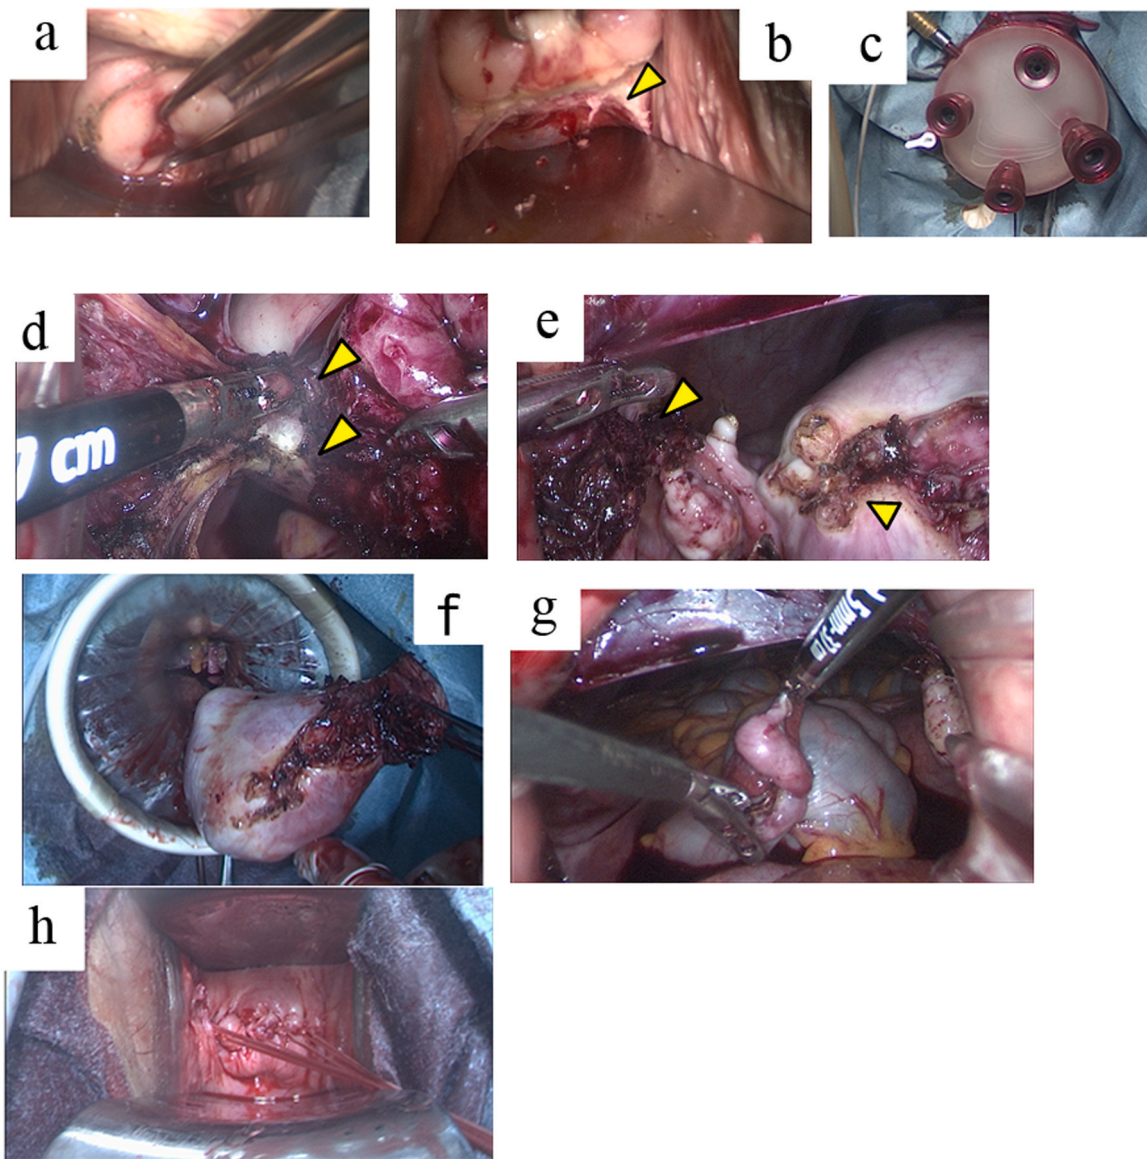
Surgical procedure. This patient with vNOTES-H and bilateral salpingectomy was a 43-year-old woman with multiple uterine leiomyomas. The largest leiomyoma was 4.0 cm in diameter, as detected by MRI on outpatient inspection, and the size of the whole uterus was 58 × 56 mm, as detected by TVUS. She was administered an oral gonadotrophin-releasing hormone receptor antagonist, namely, relugolix. She had a history of 2 gravidity and 2 parity, and her BMI was 19.7 kg/m². The operation time was 106 min, and the blood loss was 22 ml. The weight of the uterus was 144 g. (a) The vaginal mucosa was circumferentially incised at the junction of the vagina and cervix. (b) The opened Douglas fossa (Arrow). (c) Transvaginal access platform, namely, GelPOINT V-Path with one 10 mm and three 5 mm sleeves. (d) Right cardinal ligament (Arrow). (e) Right utero-ovarian ligament (arrows). (f) The resected uterus was removed from the vaginal wound. (g) After removing the uterus, bilateral salpingectomy was performed. (h) The vaginal wound was sutured.
